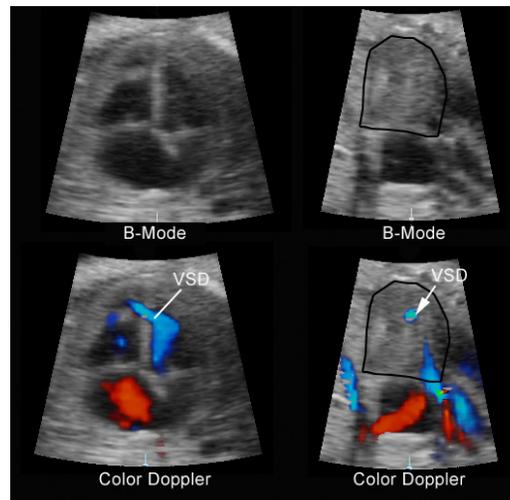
This is a STIC acquisition of the four-chamber view. The upper and lower panels are identical images, except for display of the color Doppler in the lower panel. The upper panel demonstrates the four-chamber view in the X plane and an “enface” view (outlined by black line) of the ventricular septum in the Y plane. Careful examination does not suggest any pathology of the interventricular septum. The lower panel, with color Doppler activated, demonstrates a shunting ventricular septal defect near the apex in the X plane. The size and location of the septal defect is clearly identified in the “enface” view of the Y plane.
